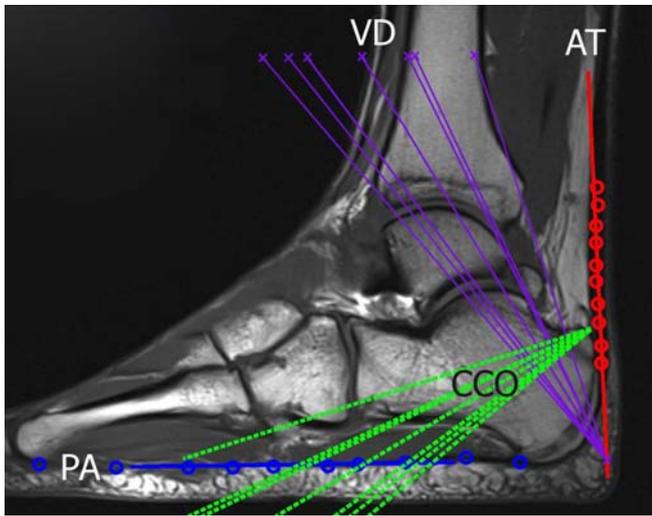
Custom software routines written in Matlab (Mathworks, Natick, MA) were used to calculate the optimal CO angle on sagittal T1-weighted MR images ($n=58$) at the level of the fourth metatarsal bone. The PA and the AT were marked with 10 points to calculate the force direction. Based on the force direction of the PA, and AT, and the 7 different values for the force ratio (F_{pa}/F_{ad}), 7 resultant force vector directions (VD) were calculated on each MRI. The optimal CO angle relative to the foot sole was determined by the line CCO that is perpendicular to VD.
